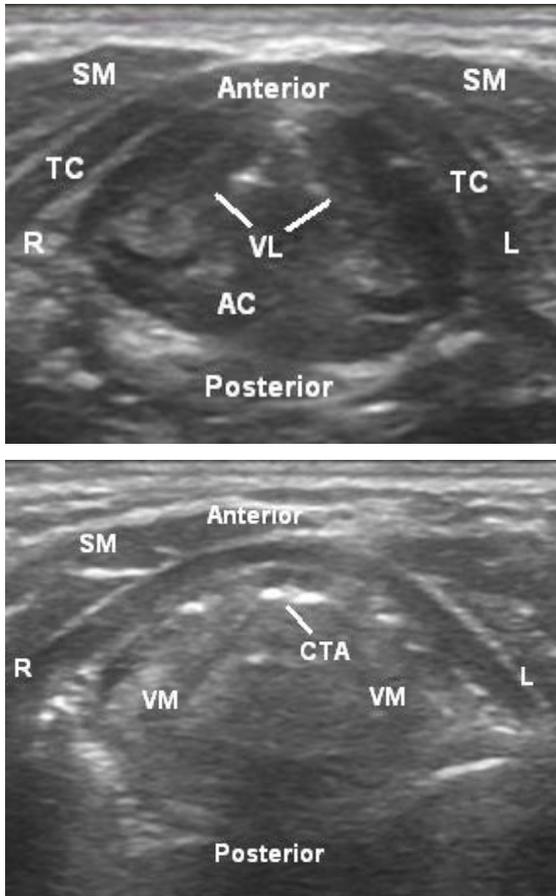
2 Images of airway at the vocal cord level, using ultrasonography
